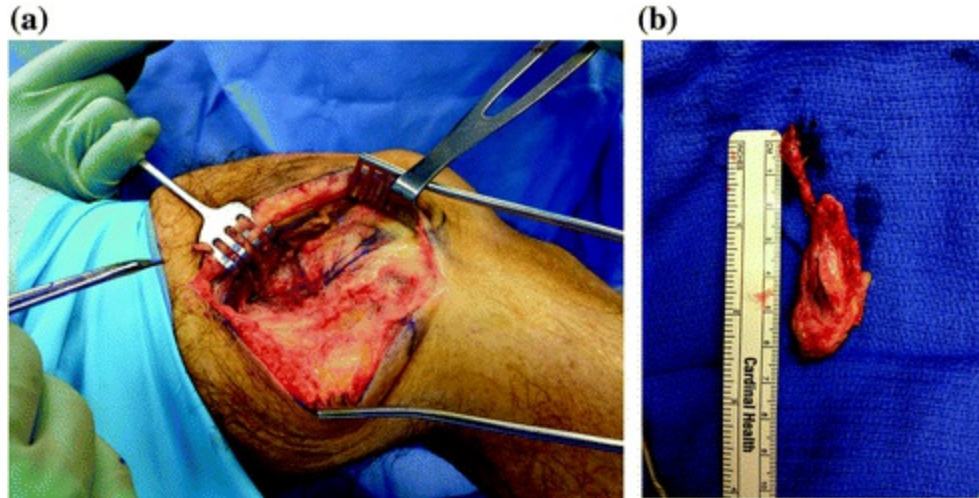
The medial femoral condyle-free vascularized graft is ideal for small areas of necrotic bone. The harvest site is easily identifiable (a) and yields a graft that can be interposed into areas of bony loss (b), particularly useful in the distal aspects of the extremities. (Image courtesy of John S. Reach, Jr., MSc, MD, Yale University School of Medicine, New Haven CT, USA)
